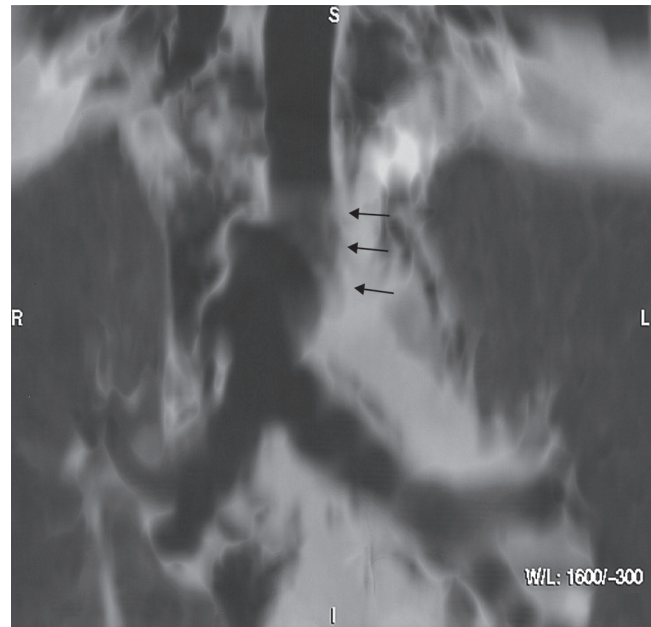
■ Tracheal rupture after a motor vehicle crash in a patient with no respiratory symptoms and a chest radiograph demonstrating pneumomediastinum. Coronal reformations of computed tomography (2.5-mm collimation) show pneumomediastinum and discontinuation of the trachea (*arrows*).
